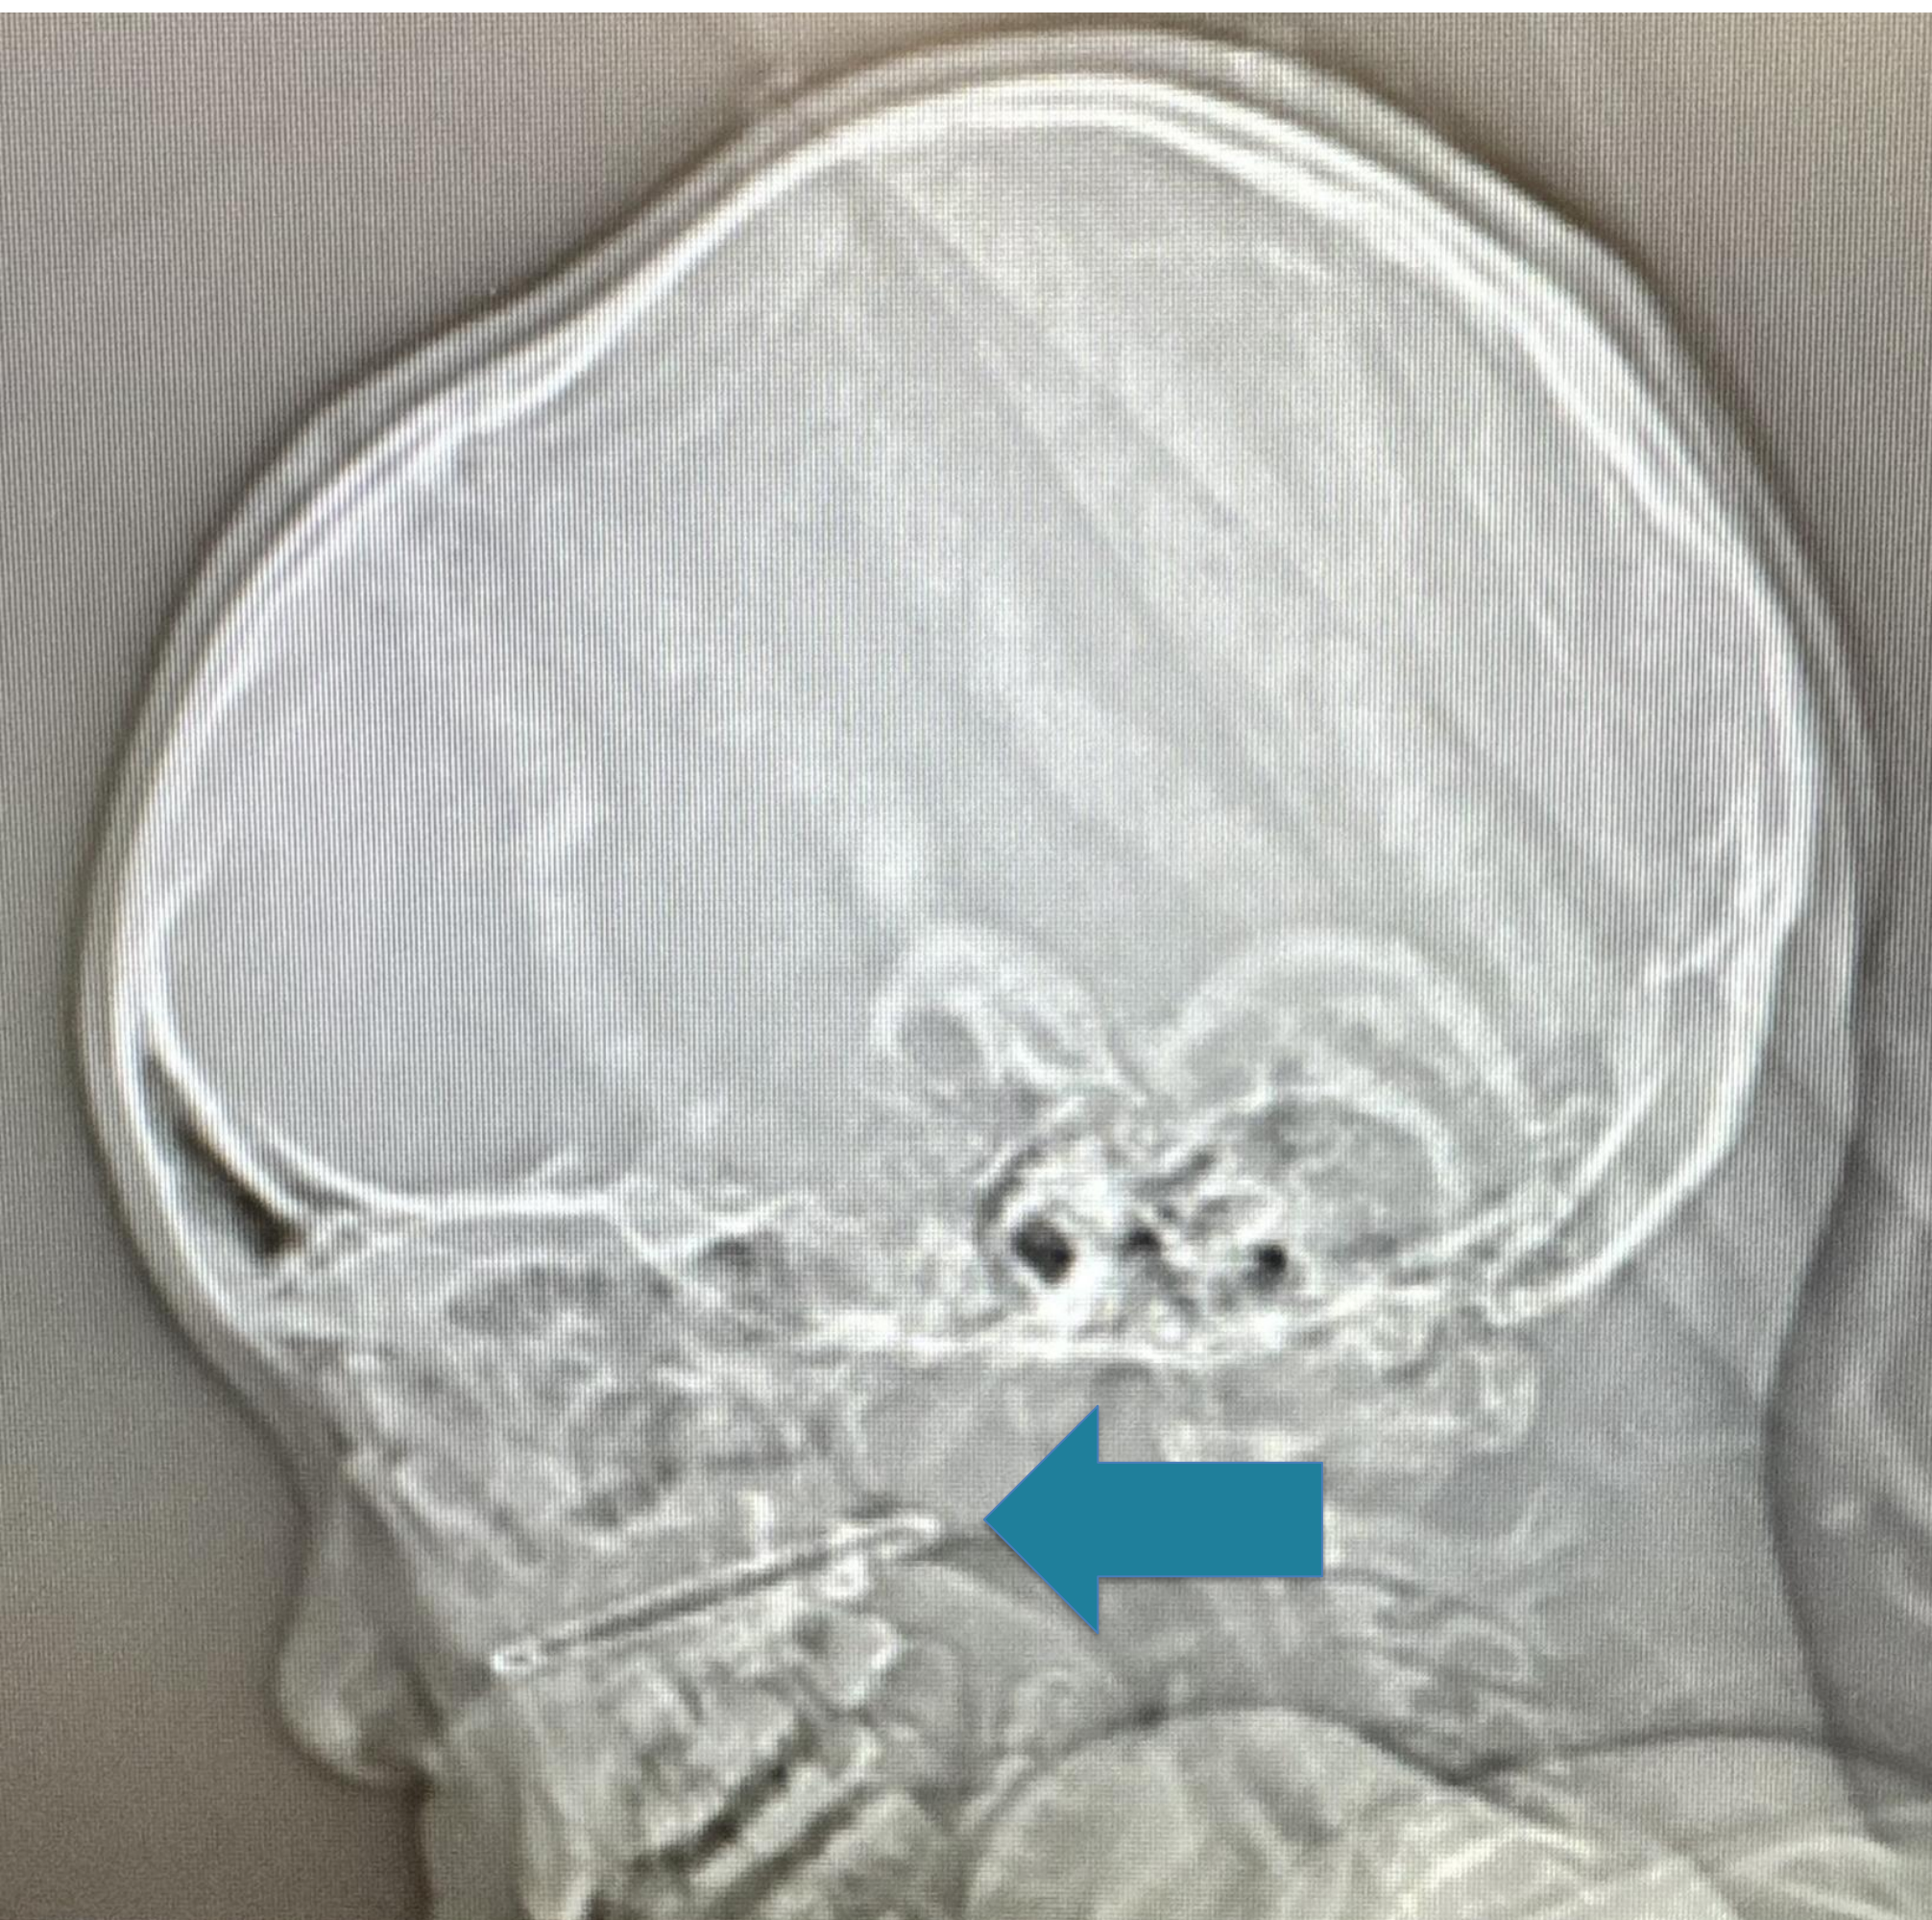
Preoperative scout CT image. Arrow denotes previously closed safety pin not seen on CT head reformatted cuts
